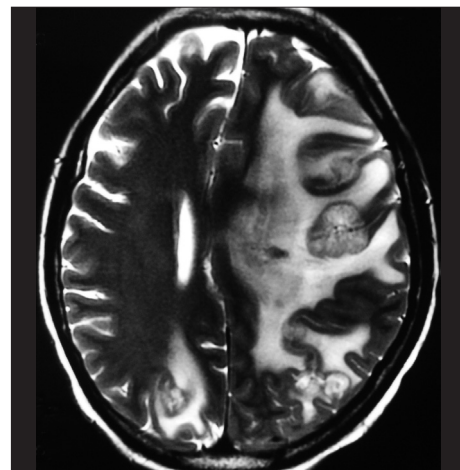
T2-weighted magnetic resonance study shows multiple tumours in both cerebral hemispheres seven months prior.
